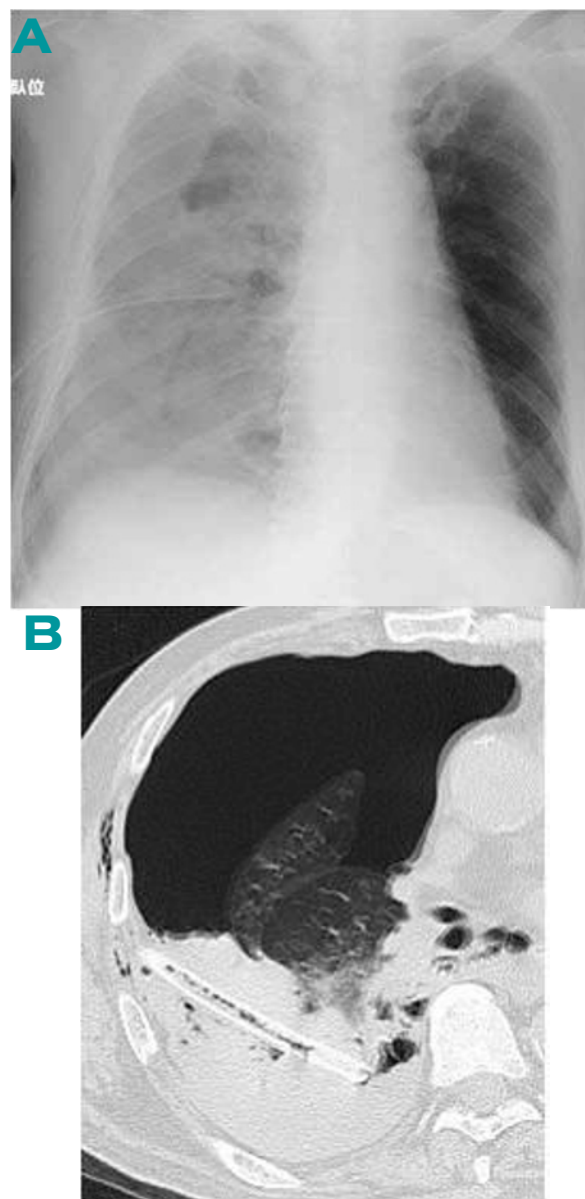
Chest radiograph at the time of deterioration of hemopneumothorax with mediastinum shift (A), and chest CT scan, which indicated bloody clot in the chest tube inserted and deterioration of pneumothorax with medium amount of pleural fluid (B).
